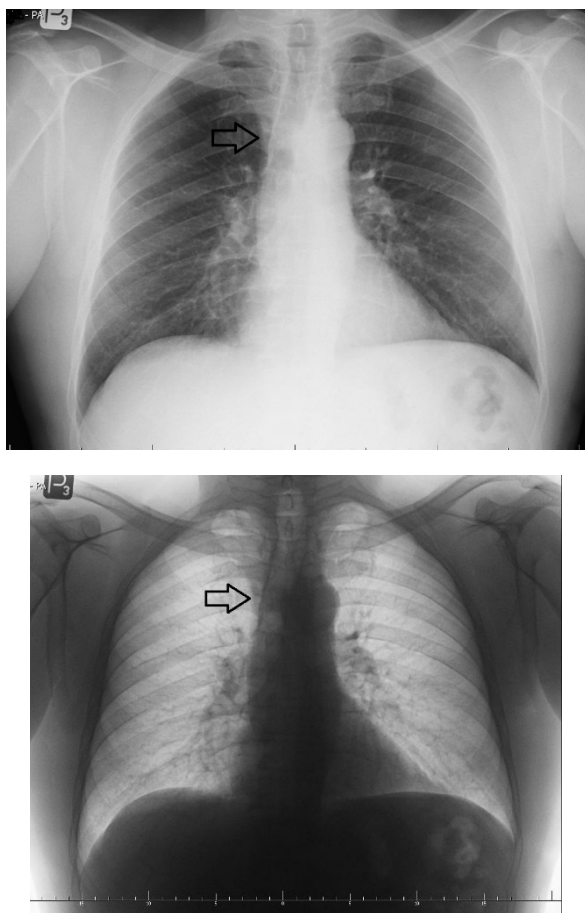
Chest radiograph in antero-posterior projection, arrows point to a shadow in the distal 1/3 of the trachea
